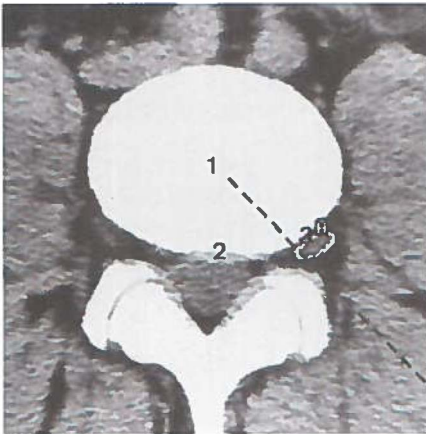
CT scan at a high level through the disc L4-L5 and the inferior endplate of vertebra L4. Needle placement high in disc L4-L5 (represented by dotted line) will puncture the L4 nerve root. 1. inferior endplate vertebra L4; 2. disc L4-L5; 3. L4 nerve root outlined. (Photograph: Dr. J.T. Wilmink, Department of Neuroradiology).
